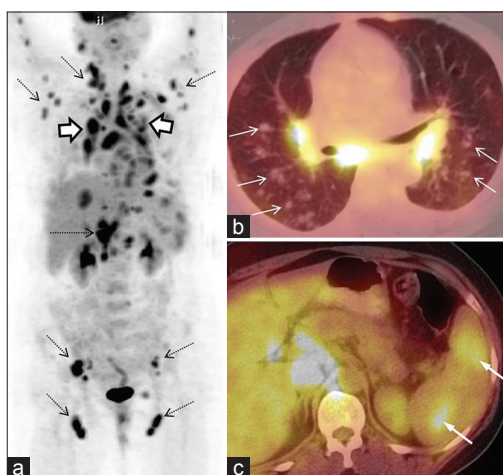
(a-c) A 31-year-old female with sarcoidosis, for baseline evaluation. Maximum intensity projection positron emission tomography (PET) image (a) revealed multiple enlarged ¹⁸F-2-fluoro-2-deoxy-glucose (¹⁸F-FDG) avid cervical, axillary, mediastinal, portal, retroperitoneal and inguinal lymph nodes (broken arrows). Note is made of the “lambda sign” due to typical symmetrical ¹⁸F-FDG avid mediastinal lymph nodes involvement (a, bold arrows) transaxial PET/computed tomography images demonstrating lung (b, arrows) and splenic (c, arrows) involvement
